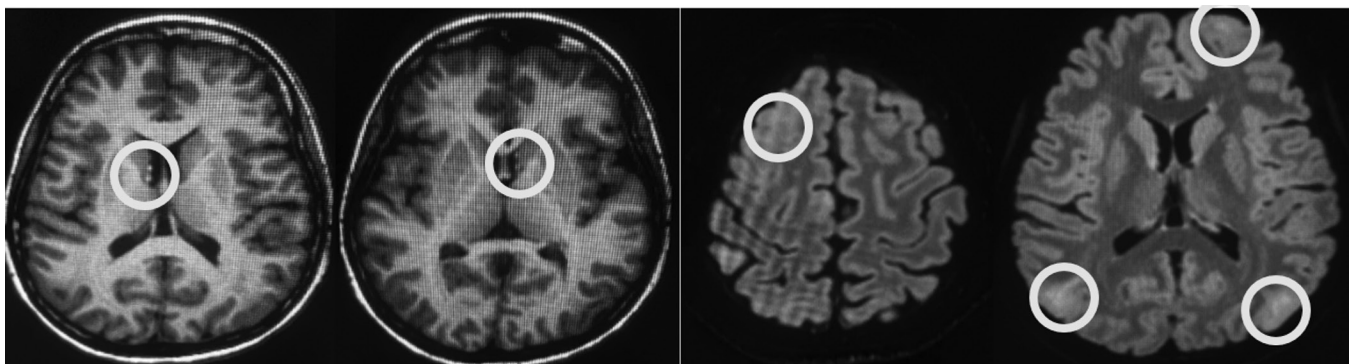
Contrast-enhanced magnetic resonance imaging of the brain showing multiple cortical tubers consistent with tuberous sclerosis.
